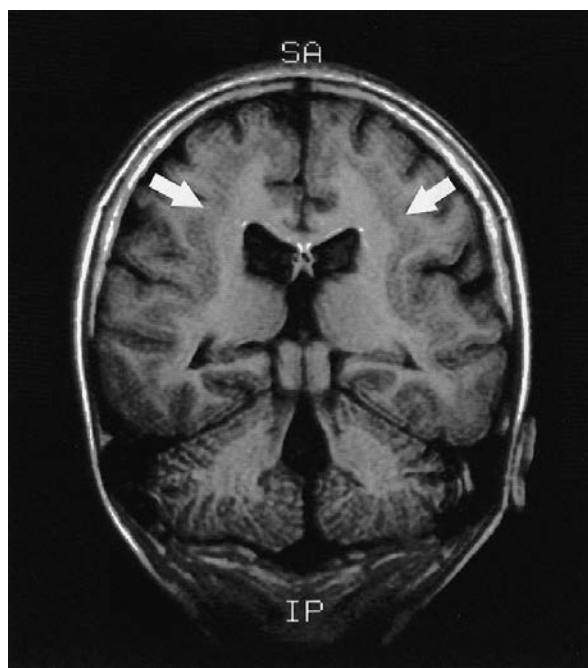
Double cortex. Coronal MRI image shows a band of heterotopic grey matter (arrows) between the cortex and the lateral ventricles.
